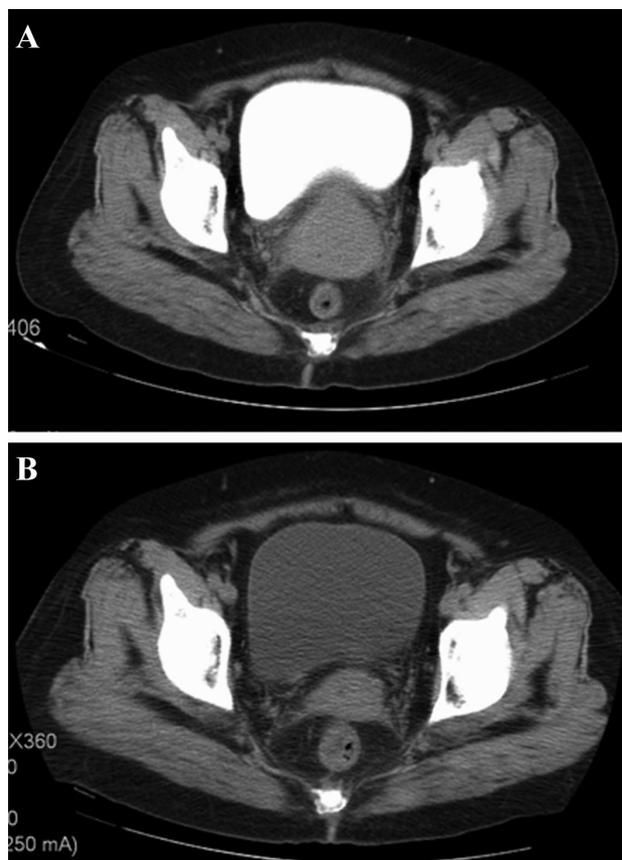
A) CT before radiotherapy shows obvious space-occupying lesions and significant thickening of the cervix with inhomogeneous enhanced. No other distant metastases are revealed in uterus, bladder, rectum, and rectouterine depression. B) Post-irradiation CT reveals no obvious space-occupying lesions, no significant thickening of the cervix, and no enlarged pelvic lymph nodes.
